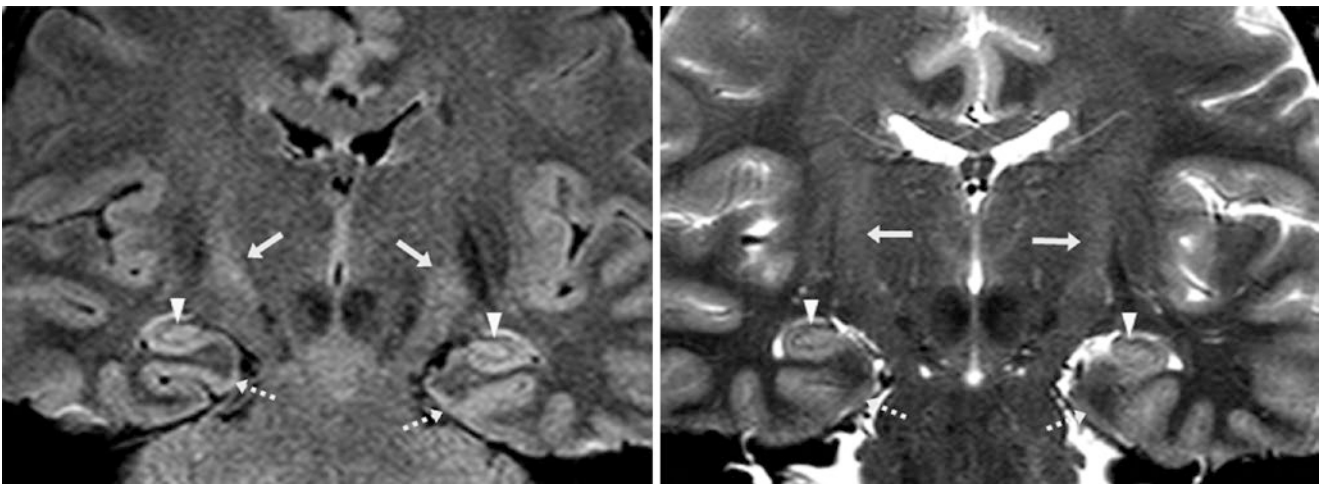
A 37-year-old with transient ischemic symptoms underwent a 3 T MRI that was interpreted as negative. The MRI demonstrated normal hyperintensity of the cortices of the hippocampi
